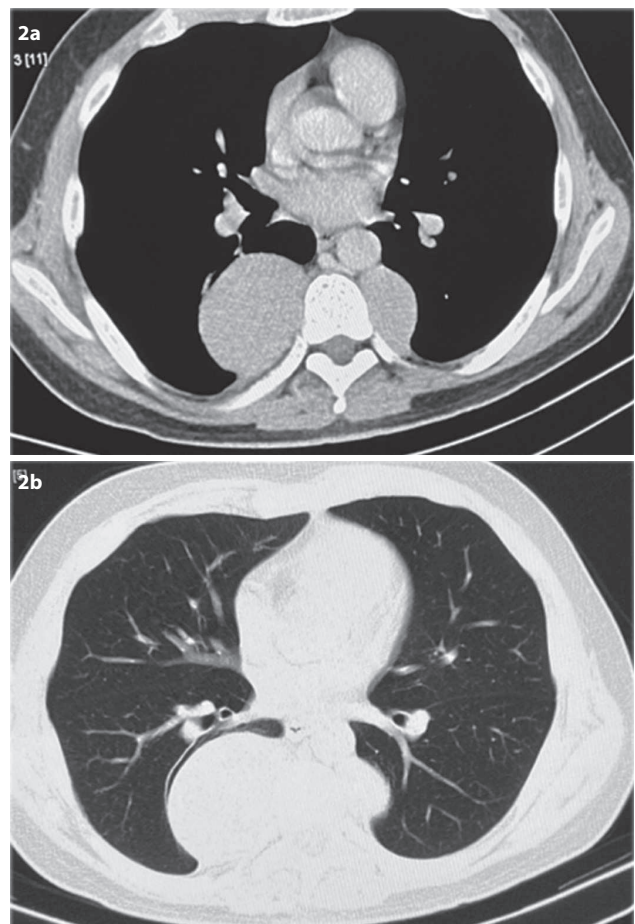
Chest computed tomography (CT), mediastinum and lung window, confirming the presence of hypodense lesions at both paravertebral sides.
